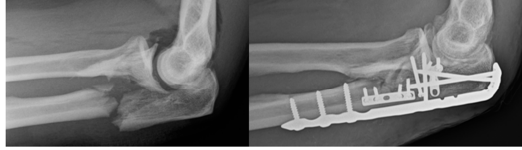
Preoperative and postoperative radiographs of a trans-ulnar basal coronoid injury that required medial plating of the separate coronoid fragment in addition to a provisional medial plate for the ulna reduction prior to placement of the olecranon plate.
